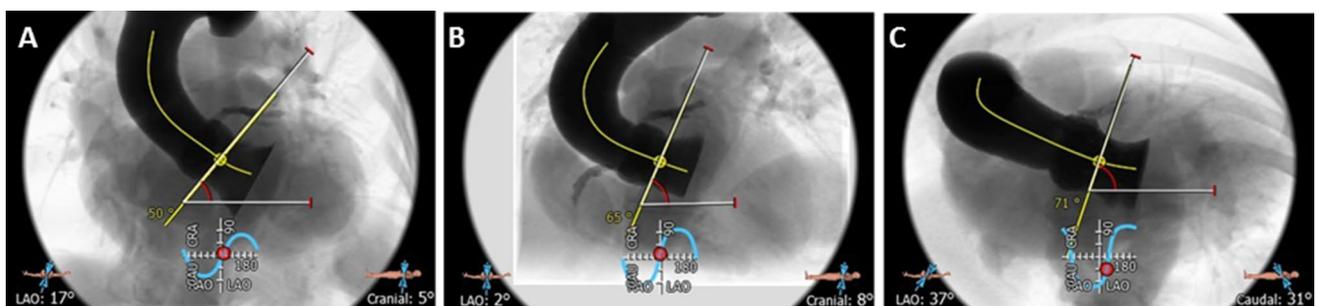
Aortic Angulation (AA) was calculated starting from the CT images. An angiographic nadir view was derived with 3mensio and AA was calculated at the level of the aortic annulus and was defined
